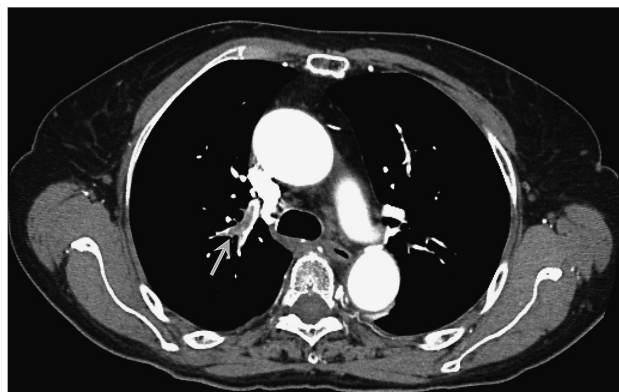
A 77-year-old woman underwent initial total knee arthroplasty due to right knee osteoarthritis. Contrast-enhanced computed tomography was performed 6 days after surgery. Thrombosis was detected in the segmental branches of the right pulmonary artery (arrow). Mild hypoxemia was observed on the first day after surgery, and follow-up observation was conducted during oxygen administration. Right atrial overload was noted on an echocardiogram obtained by a cardiovascular specialist, consistent with a diagnosis of symptomatic PE.
